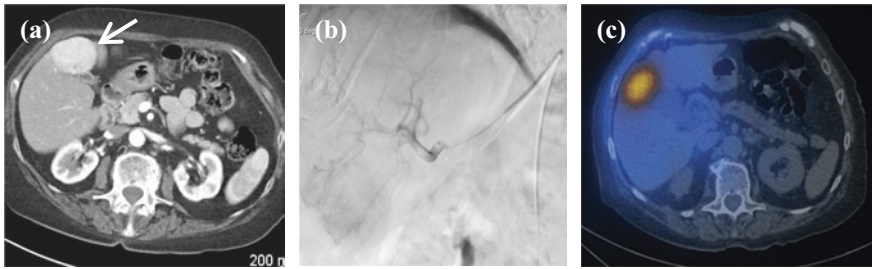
An 83 year old female presented with hepatocellular carcinoma which had progressed despite recent therapy. a An arterially enhancing lesion liver is seen on coronal axial CT. b Selective Internal Radiation Therapy (SIRT) was performed by selectively delivering Yttrium-90 microspheres to the tumour via an intra-arterial catheter placed in the right hepatic artery. c Post treatment SPECT-CT images show excellent uptake within the tumour
